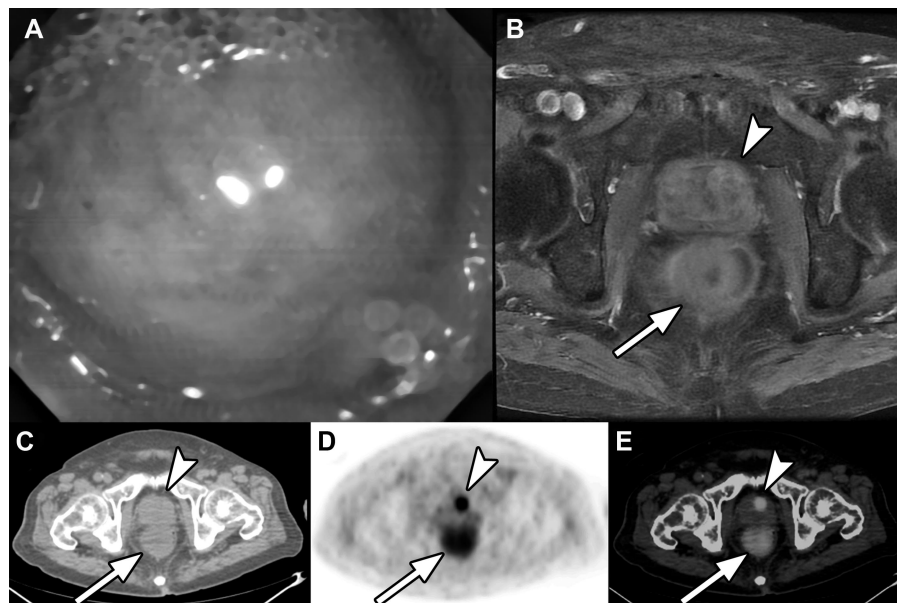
An 84-year-old man with a history of hypertension and arrhythmia presented reduction in diameter of stool and tenesmus for 6 months. Otherwise, he complained of bloody stool once. Digital rectal examination revealed a protruding mass approximately 5 cm from anal verge. Subsequently, he underwent routine laboratory studies, colonofiberscopy, MRI of pelvis, and FDG PET/CT for systemic survey of suspicious of rectal cancer. Routine laboratory studies, including complete blood count, serum chemistries, and tumor markers, were within normal limits except elevated serum PSA (61.359 ng/mL). Colonofiberscopy (A) revealed a round and elastic submucosal mass with smooth surface; biopsy of the rectal tumor was done in the same time. MRI of pelvis (B) showed a well enhancement of submucosal tumor measuring 5.4×4.3 cm in size in the rectum (arrows). Accidentally, an asymmetrically enlarged prostate gland with heterogeneous enhancement was noted in the same time (B; arrowheads). In addition, FDG PET/CT (C–E) demonstrated abnormally increased FDG uptake in rectum (SUV_{max} : 3.33; arrows) and prostate simultaneously (SUV_{max} : 5.66; arrowheads). Thus, he also underwent transrectal ultrasonography and prostate biopsy. Ultimately, biopsies of rectal tumor and prostatic gland confirmed diagnoses of synchronous schwannoma and adenocarcinoma.
